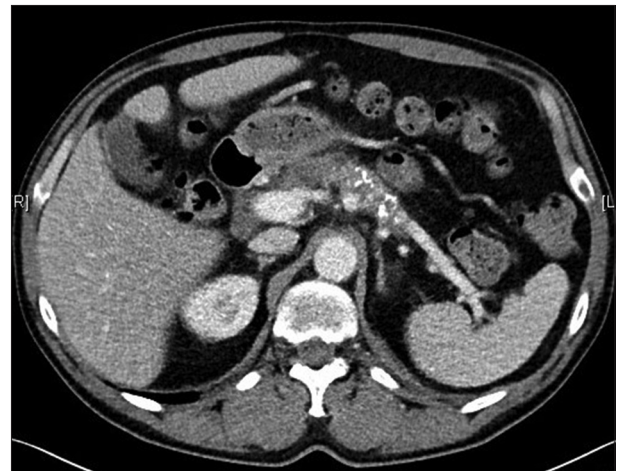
Computed tomography of the abdomen showing chronic pancreatitis with calcifications but cannot identify the source of gastrointestinal bleeding
